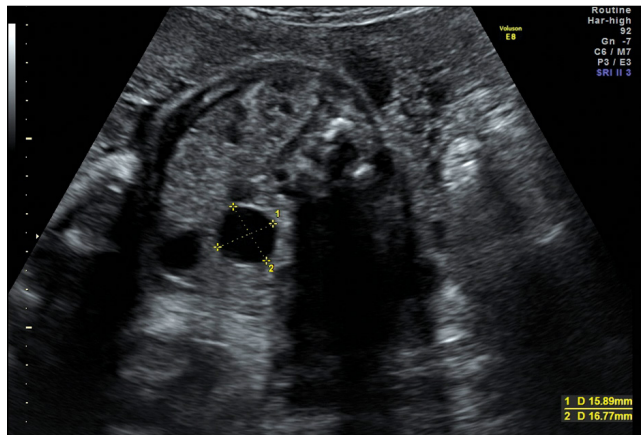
Prenatal ultrasonographic scan showing a fetal anechoic ovarian cystic mass measured 15x16 mm, with bladder shown inferiorly at 29 weeks of gestation.
